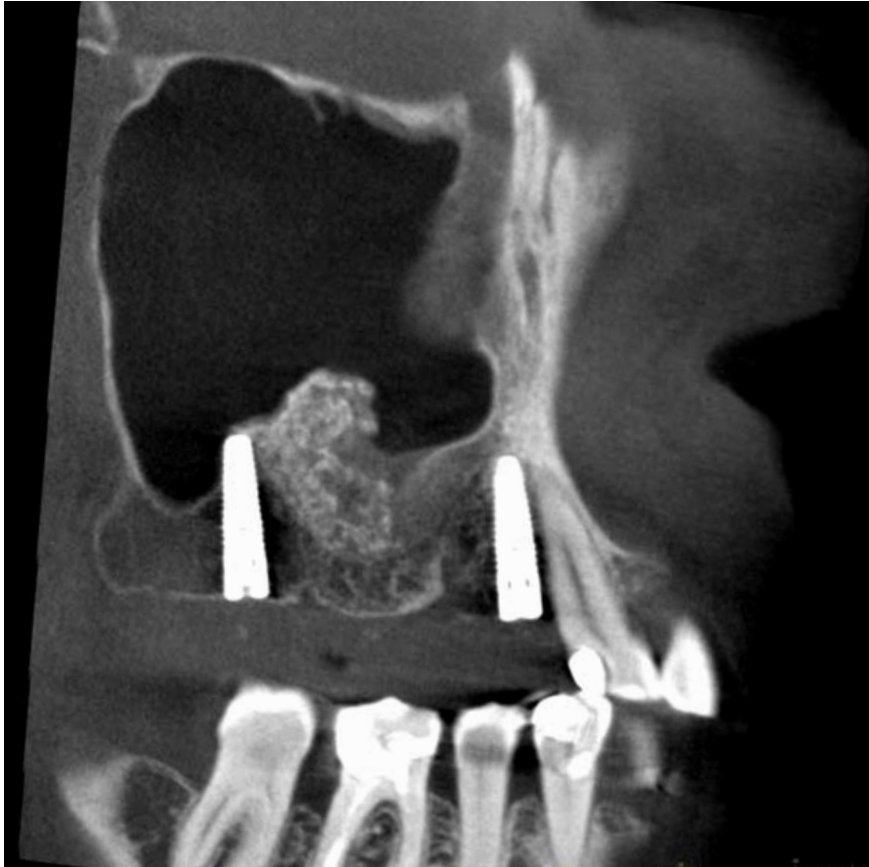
Sagittal CBCT image of the right maxillary sinus
